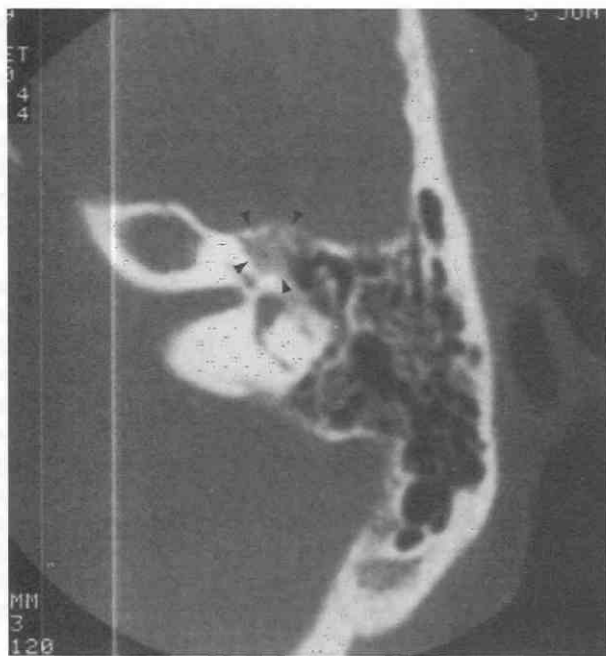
Facial nerve hemangioma in a patient with slowly progressive facial paralysis. The axial CT section through the left temporal bone shows mixed sclerosis and destruction of the geniculate ganglion region (arrowheads). The normal smoothly margined canal is not visible and is replaced with an irregular cluster of calcification. There is no soft tissue component within the middle ear.
